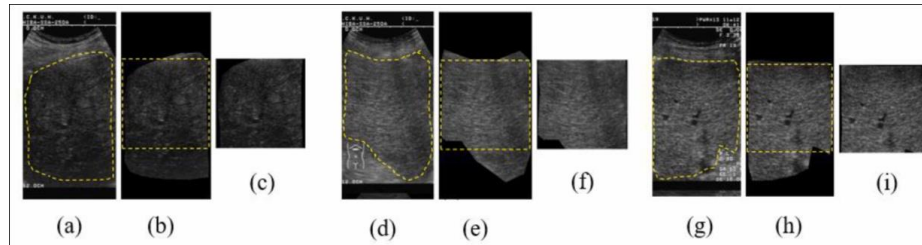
Ultrasound Images for Classification and Model Building
